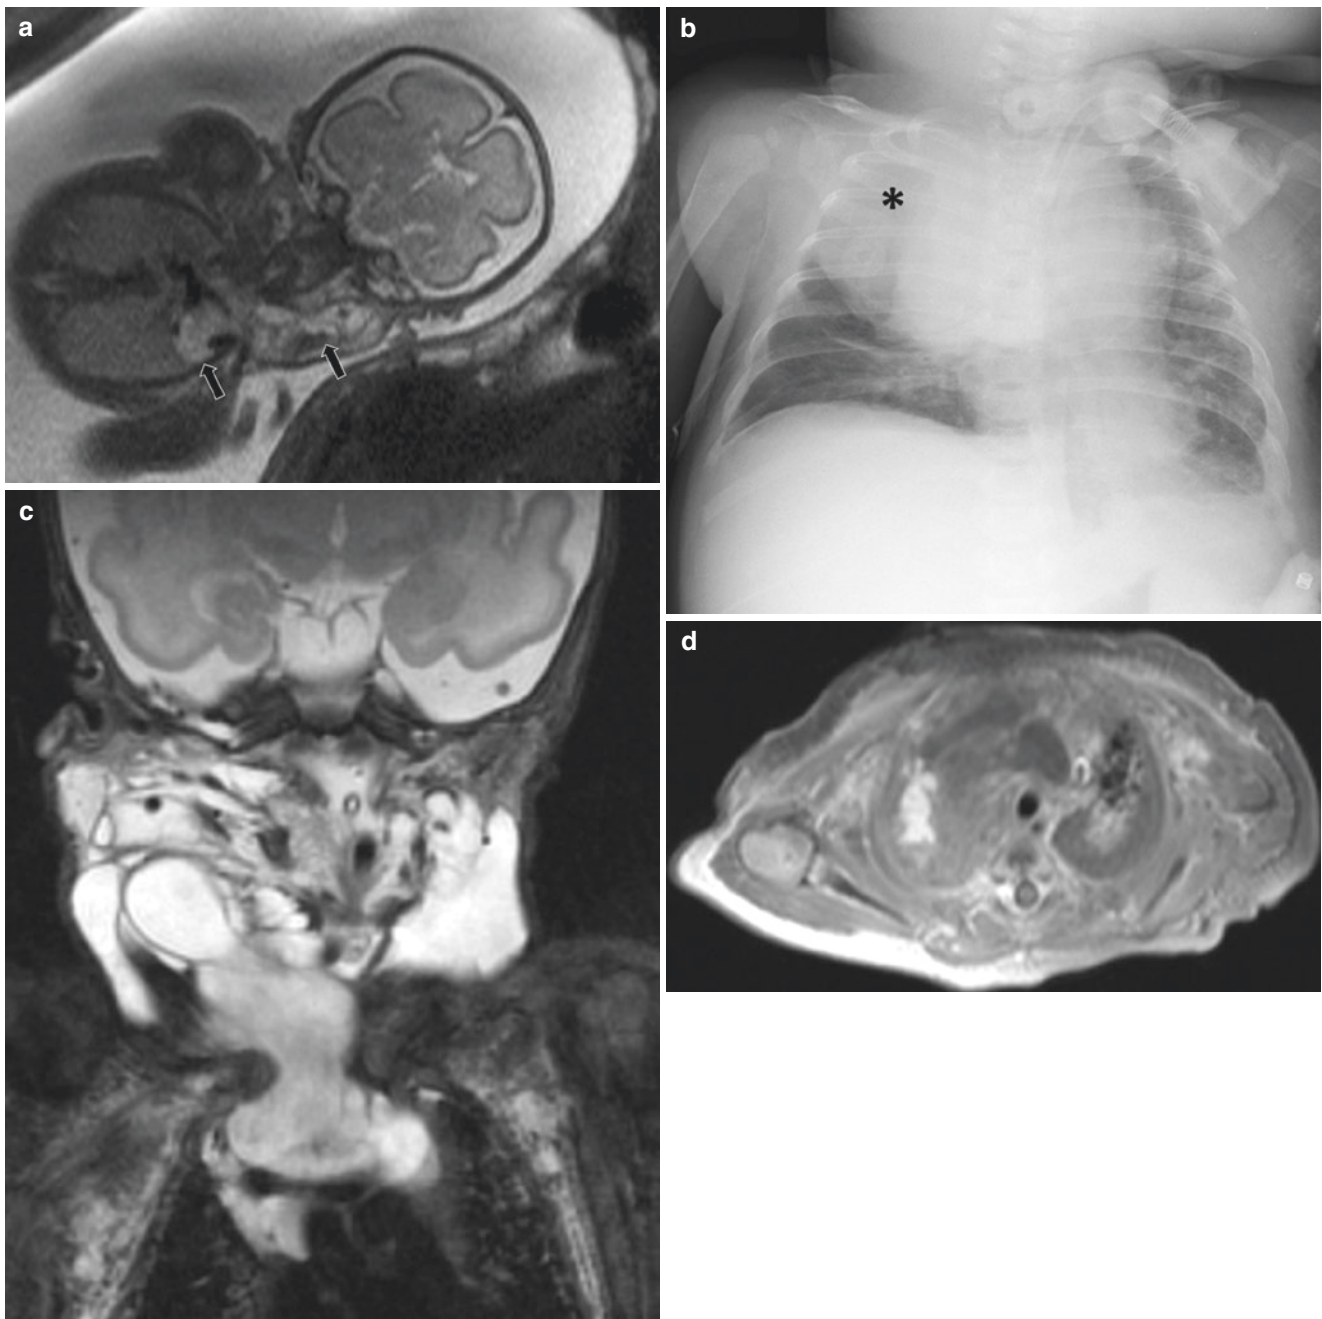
4-week-old girl who presented with a palpable right sided neck mass on physical examination and abnormal prenatal MRI. (a) Prenatal MR image shows a large lymphatic malformation (arrows) of the neck and right chest. (b) Frontal chest radiograph demonstrates an opacity (asterisk) representing underlying intrathoracic portion of the lymphatic malformation. (c) Coronal T2-weighted MR image shows
